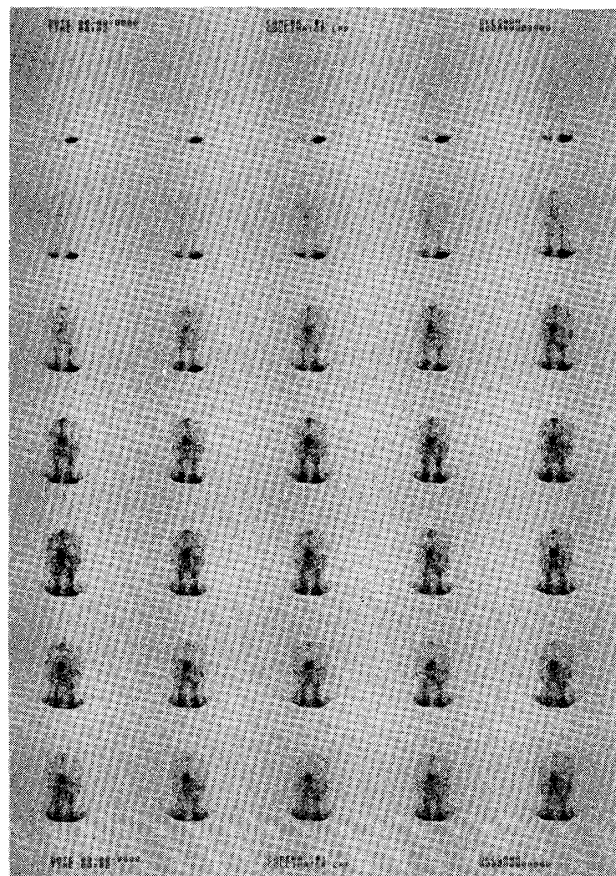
Serial scintigrams obtained in the postoperative follow up, which demonstrates a decreased bone blood flow in the incisor region of the mandible.
